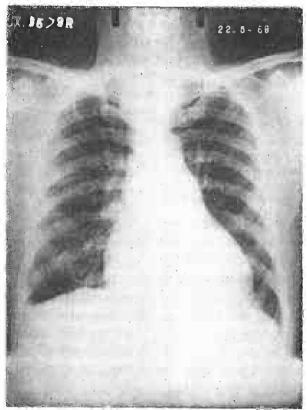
Chest radiograph showing an enlarged heart and main pulmonary arteries, with obliteration of the right costo-phrenic angle.
